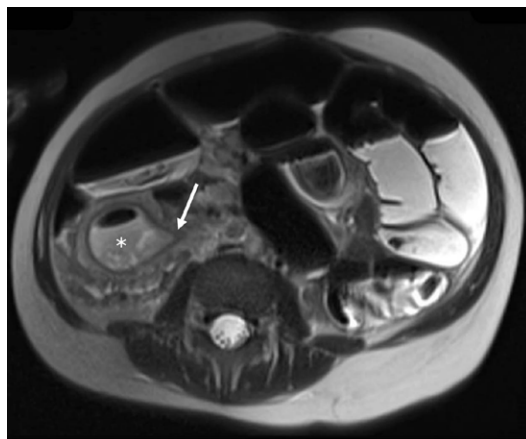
Magnetic resonance imaging showing signs of internal hernia with supposed strangulated bowel; its lumen (asterisk) and the bowel wall pinched by an intestinal loop (arrow)
